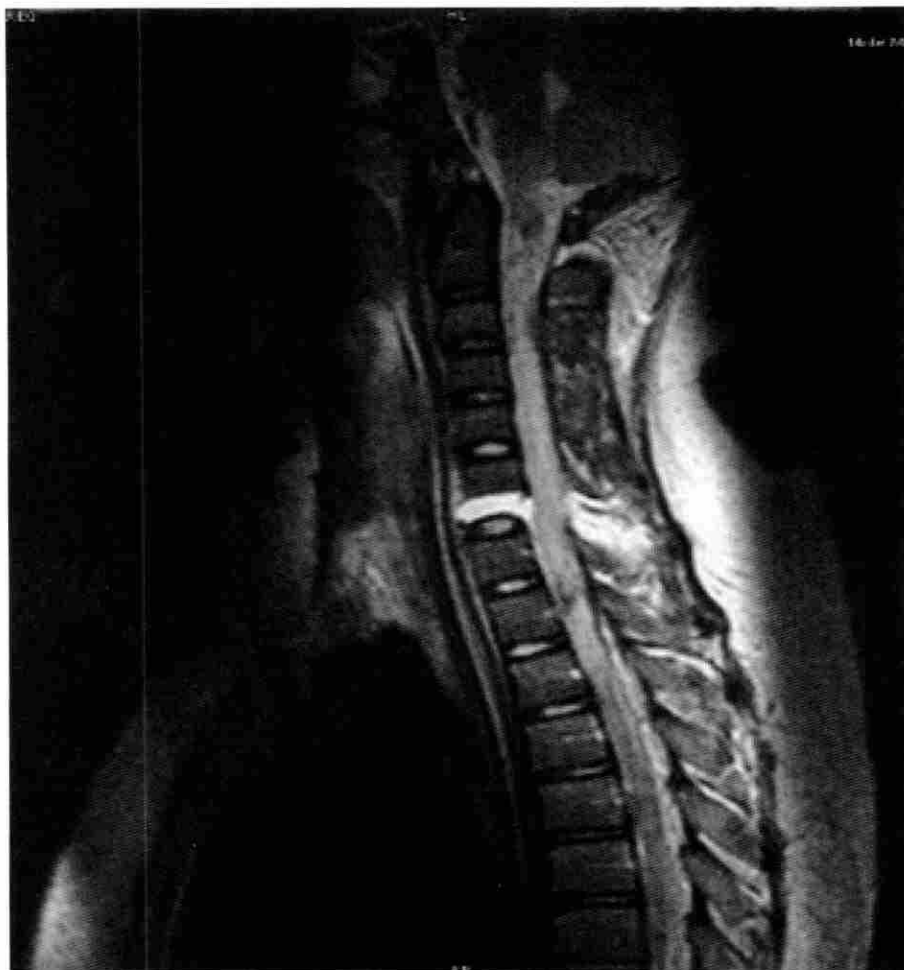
MRI showing no evidence at all of any type of supratentorial lesion. There is disruption of the C6-C7 disc and an associated disruption in the posterior elements at the same level. The defect in the neuraxis, seen in the lower part of the brainstem, was evident throughout the cervical cord, extending down to the level of T1-T2.
